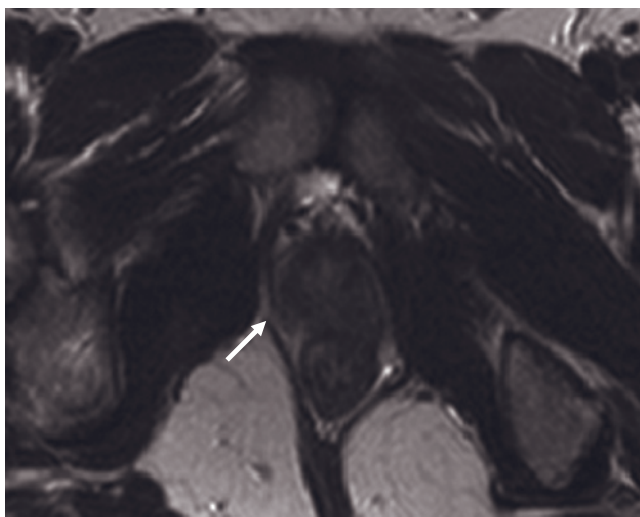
Utricular cysts. Transverse T2-weighted echo-train spin-echo with fat suppression (a) and transverse (b) and sagittal (c) T1-weighted fat-suppressed gradient-echo images. A rounded, central structure, which is high in signal intensity on the T2-weighted images, represents a utricular cyst (arrow, a). Note the lack of enhancement in the cyst relative to the surrounding prostatic parenchyma (arrows, b, c). Transverse T2-weighted spin-echo image (d) in a second patient. A utricular cyst located in the region of the verumontanum is high in signal intensity on this T2-weighted image (arrow, d). T1-weighted postgadolinium interstitial phase 3D-GE image (e) demonstrates the midline cystic structure (arrow) in the prostate that is consistent with utricle cyst in another patient. Note the fused ectopic pelvic kidney located in the pelvis.
